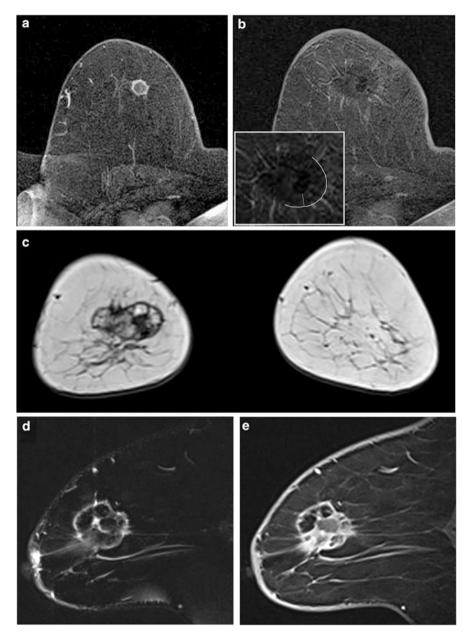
MRI-guided cryoablation (case 2). (a) Transverse contrast-enhanced fat-suppressed T1-weighted MR image demonstrates a 12 mm-sized enhanced mass without surrounding intraductal extension. (b) Transverse contrast-enhanced fat-suppressed T1-weighted MR image shows that the non-enhanced tumor is completely encased within the ablation zone. Inset shows the border of the ablation zone (*solid line*), and the minimum ablative margin (*dotted line*) is 6.5 mm. (c) Coronal T1-weighted MR image obtained 9 weeks after cryoablation demonstrates the well-delineated ablation zone. (d) Sagittal fat-suppressed T2-weighted MR image obtained 9 weeks after cryoablation demonstrates the hypointense tumor encased within the ablation zone. (e) Sagittal contrast-enhanced fat-suppressed T1-weighted MR image obtained 9 weeks
